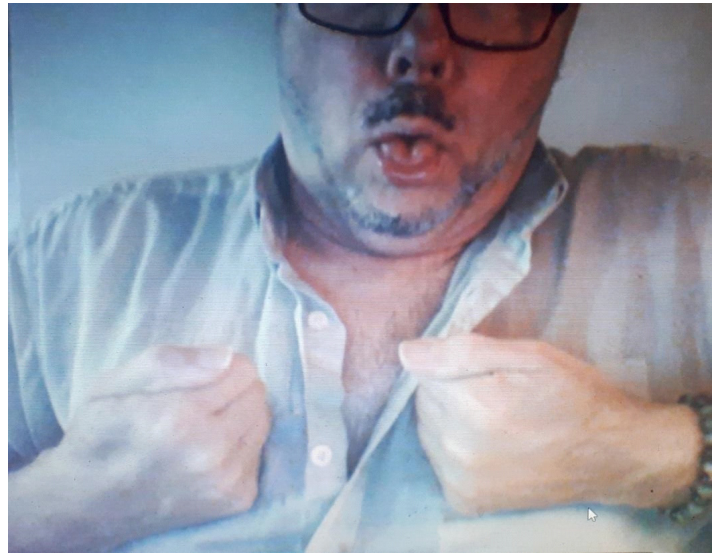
A model (the Author) is shown administering self-administered transthoracic Thrombo-Agitative Percussion (TAP) via rapid, forceful bilateral fist strikes to the left and right of the sternum, deep coughing, and upper back slams (not seen in the figure).
